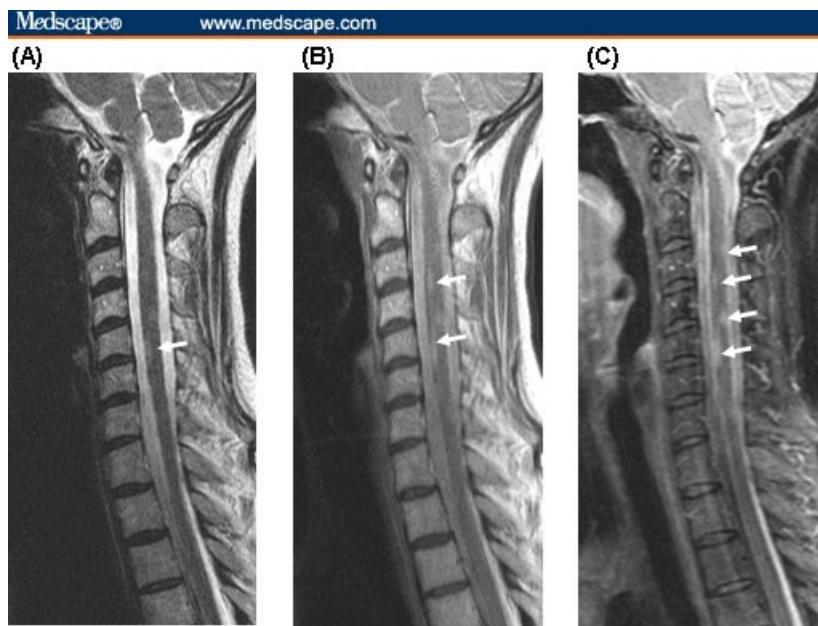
T2-weighted spinal cord images. (A) Traditional T2, (B) proton density, and (C) STIR images of the spinal cord of an MS patient. STIR images are most sensitive for detecting MS lesions.
